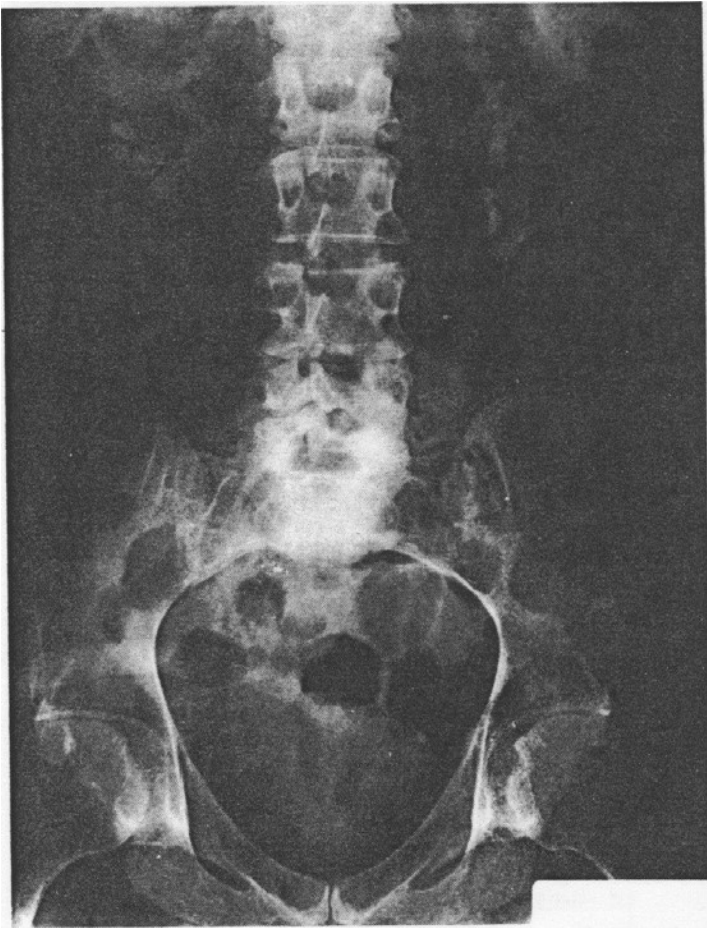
Radiograph of the abdomen of a quadriplegic person eight months after a cervical spinal cord injury. The patient had been inactive most of the time. Notice the kidney stones in the right and left kidney areas. There is extensive osteoporosis of the spine and pelvis
